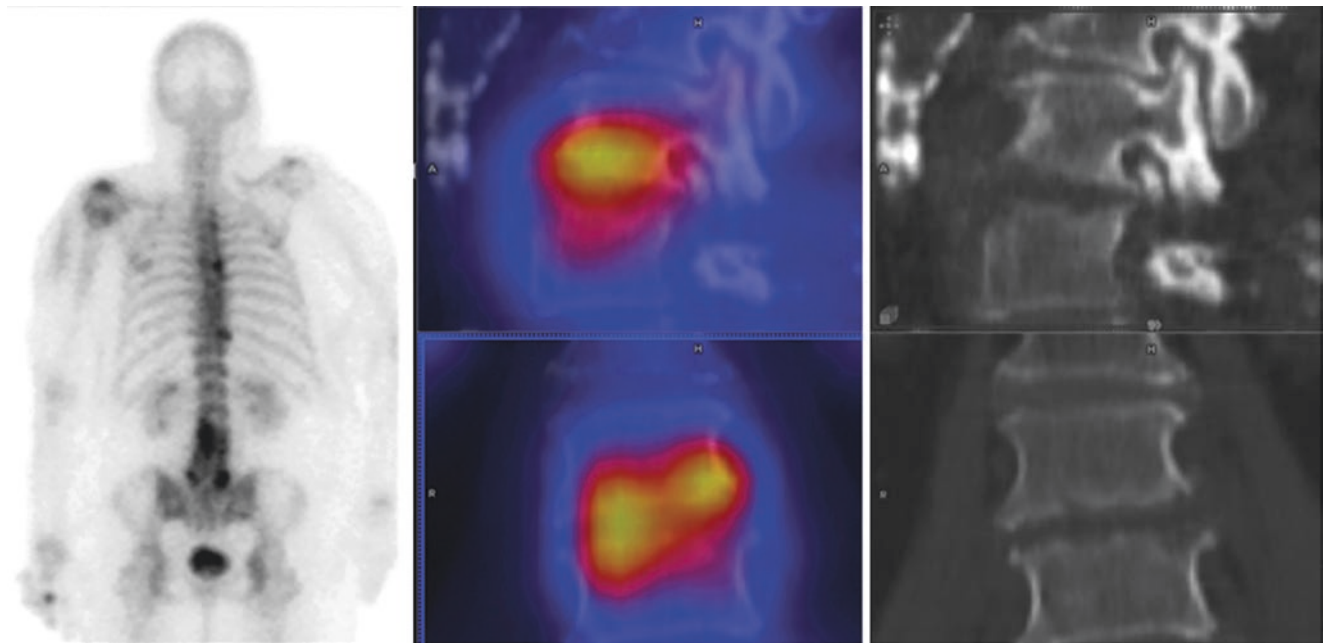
Bone scintigraphy performed in a 67-year-old woman with considerable, long-standing back pain. Dorsal view of planar scan (left panel) shows markedly enhanced tracer uptake in the lower lumbar spine extending over at least two segments. Hybrid images (center
